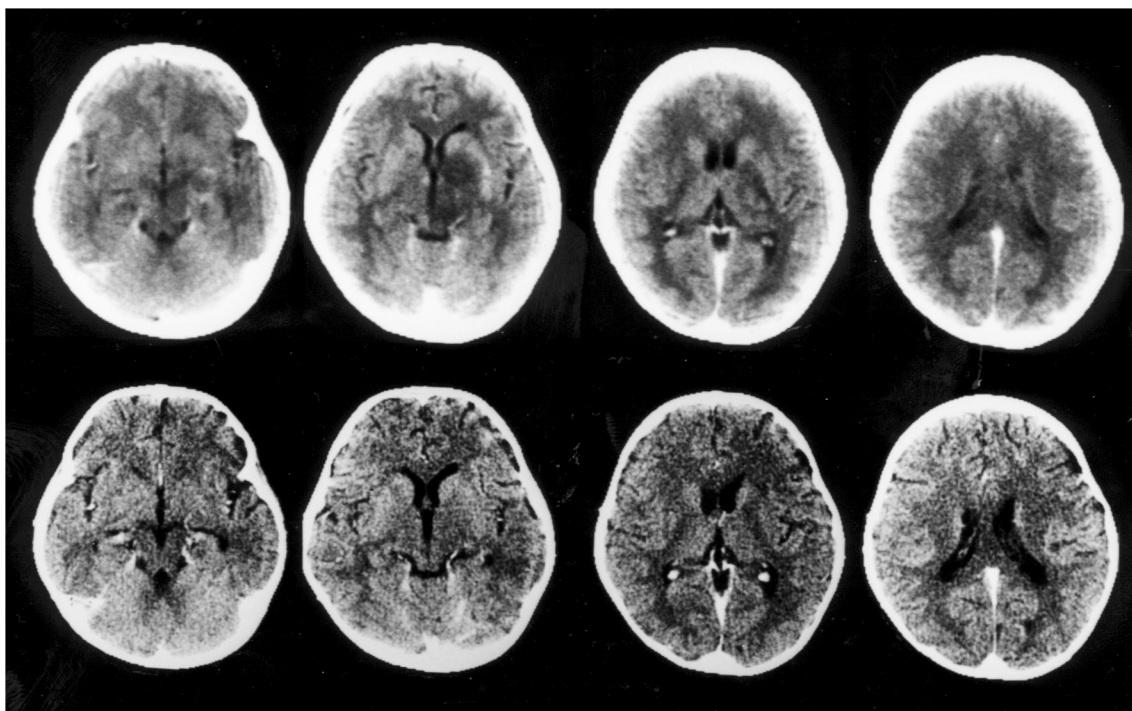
(Upper) A brain CT (Shimadzu, SCT 200N) examined on the day of her admission with contrast enhancement showed a large, diffuse and enhanced low-density lesion in the left brain including the lentiform nucleus, posterior limb of internal capsule, thalamus, posterior hypothalamus, cerebral peduncle, and superior colliculus. (Lower) Brain CT (General Electric, CT/T 8800) examined 2 weeks after the beginning of dexamethazone administration showed complete resolution of the lesion.
